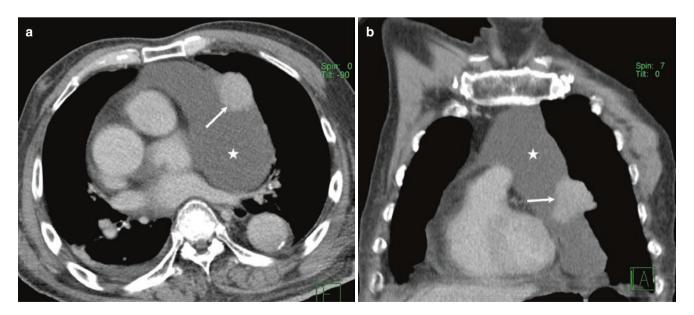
Thymoma with a large thymic cyst. (a, b) Axial and coronal CT images show a mass (arrow) with a large cyst (asterisk). Surgery revealed an invasive thymoma
